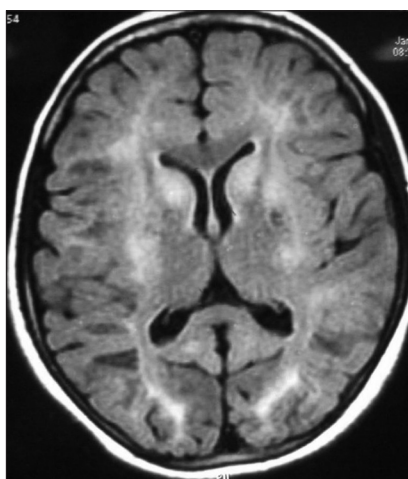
Axial T2 FLAIR image shows bilateral symmetrical subcortical and basal ganglia hyperintensities. Diffuse cortical atrophic changes are also seen
